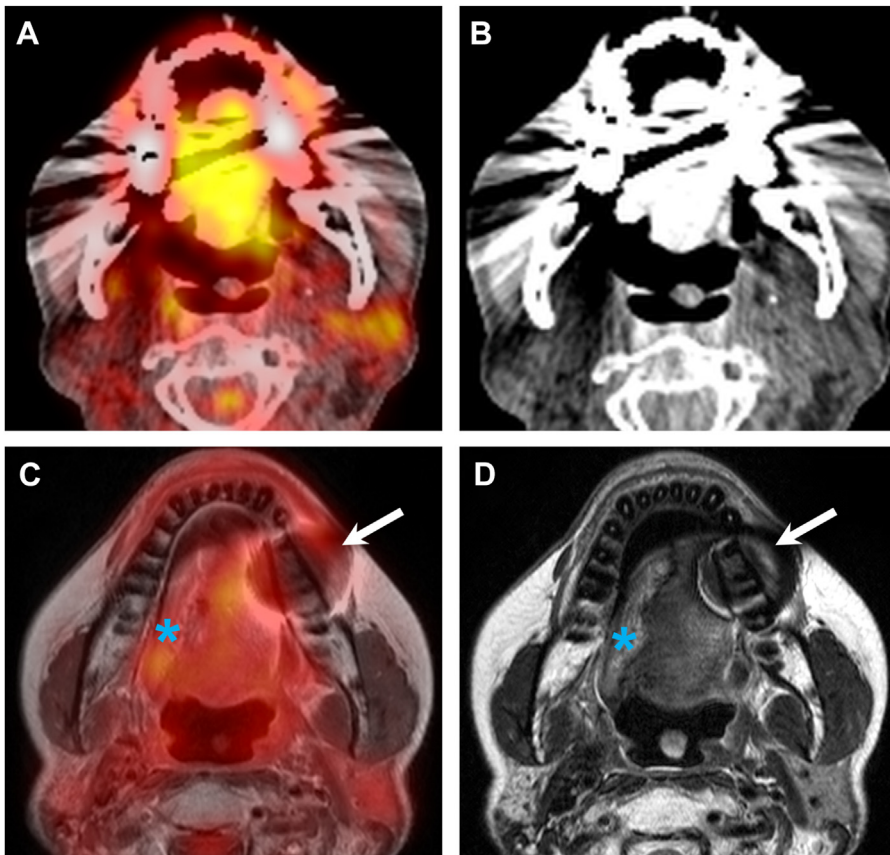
(A, B) FDG PET/CT images. (C, D) Corresponding PET/MR imaging obtained in the same patient after surgery and radiotherapy for SCC of the oral cavity. Owing to dental hardware, the oral cavity can be hardly evaluated on PET/CT; however, on PET/MR imaging, no recurrent disease can be identified. Note the relatively limited artifact due to metal implant on the left (arrows). Normal flap used to reconstruct the floor of the mouth on the right (asterisks).
